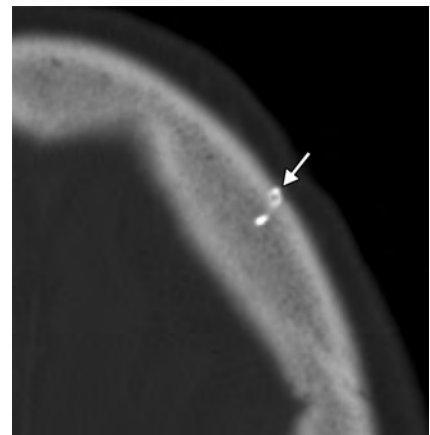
Brow lift. Axial CT image shows a metallic left frontal bone pin (arrow) used for suture fixation.
